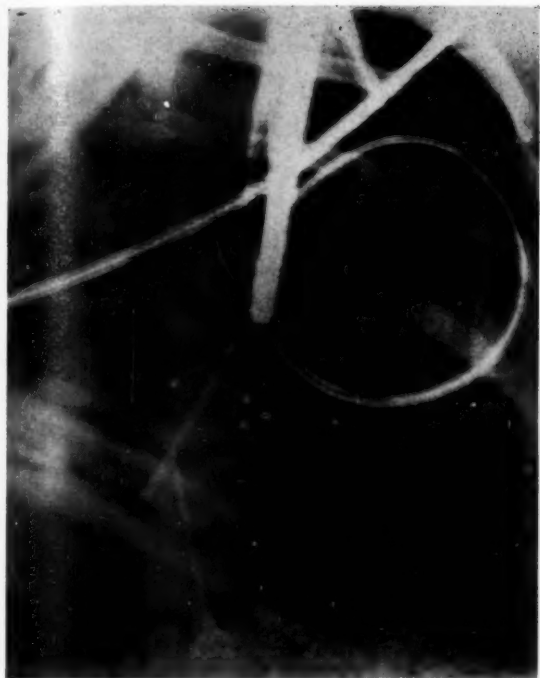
X-ray photograph of the prong-catheter expanded in the inferior vena cava, near its entrance into the right auricle. The other catheters have been positioned in the chambers of the heart for the recording of pressure.
